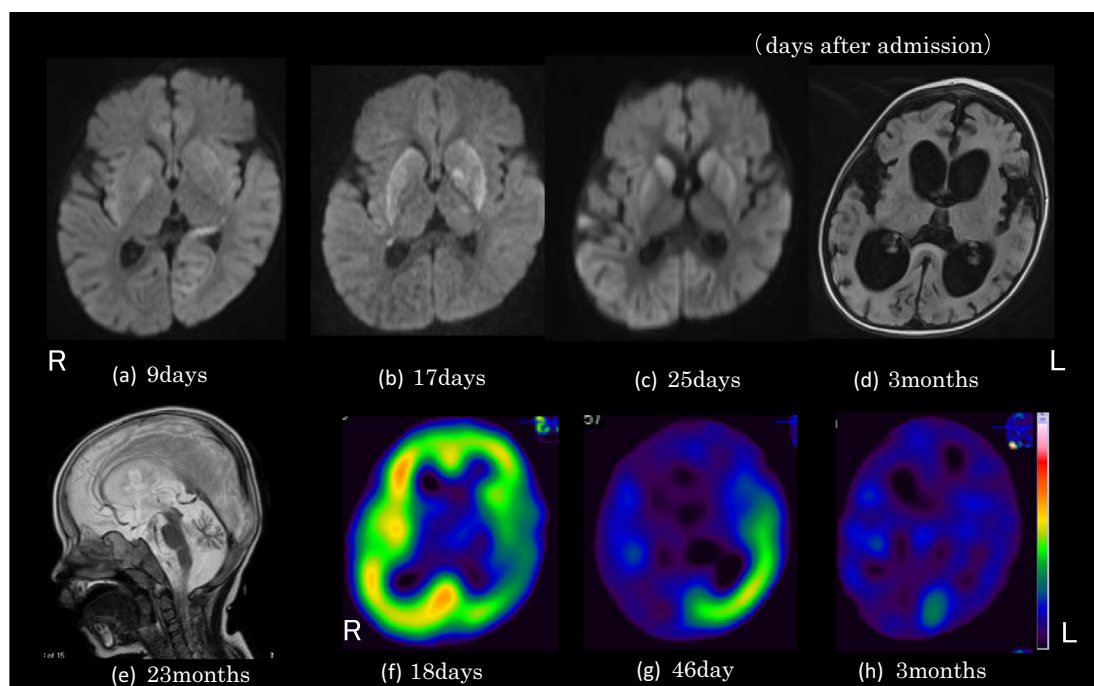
(a) DWI image of head MRI on the 9th day after admission shows high intensities in the right insular cortex, right globus pallidus, a part of the bilateral hippocampus, bilateral fornix, left caudate nucleus, and left occipital gray matter. (b) DWI image on the 17th day after admission shows high intensity regions in the bilateral basal ganglia. (c) DWI image on the 25th day after admission. The high intensities previously observed in the basal ganglia are weaker, but are detected in broad regions throughout the cerebral cortex. (d) FLAIR image 3 months after admission. Severe cerebral atrophy is observed. (e) T2-weighted image. Cerebellar atrophy was manifested at 23 months of age. (f) IMZ-SPECT shows a decrease in binding of ^{123}I -iomazenil predominantly in the left temporal region on the 18th day of hospitalization. (g) Repeated IMZ-SPECT on the 46th day of hospitalization demonstrates almost no accumulation across a broad region, sparing the left temporal region. (h) Three months after admission, almost no reactivity is observed in the cerebrum.
